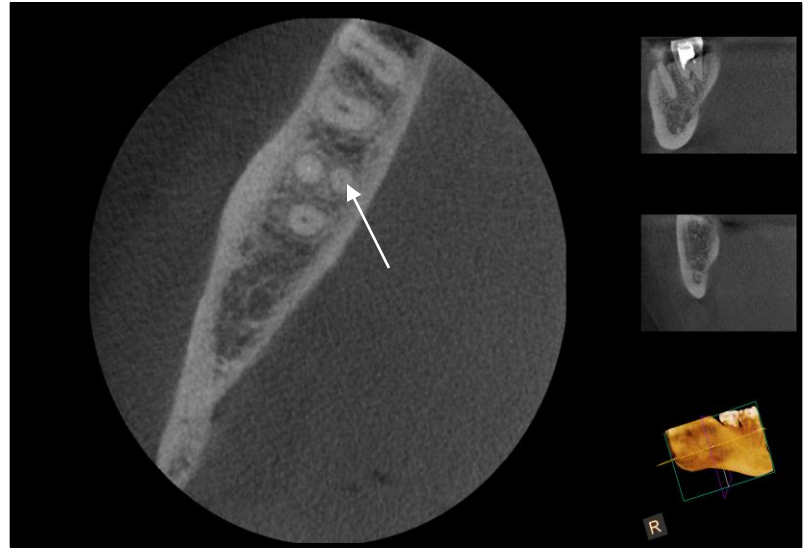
Axial CBCT slice showing separate mesio lingual root in the mid & apical third
